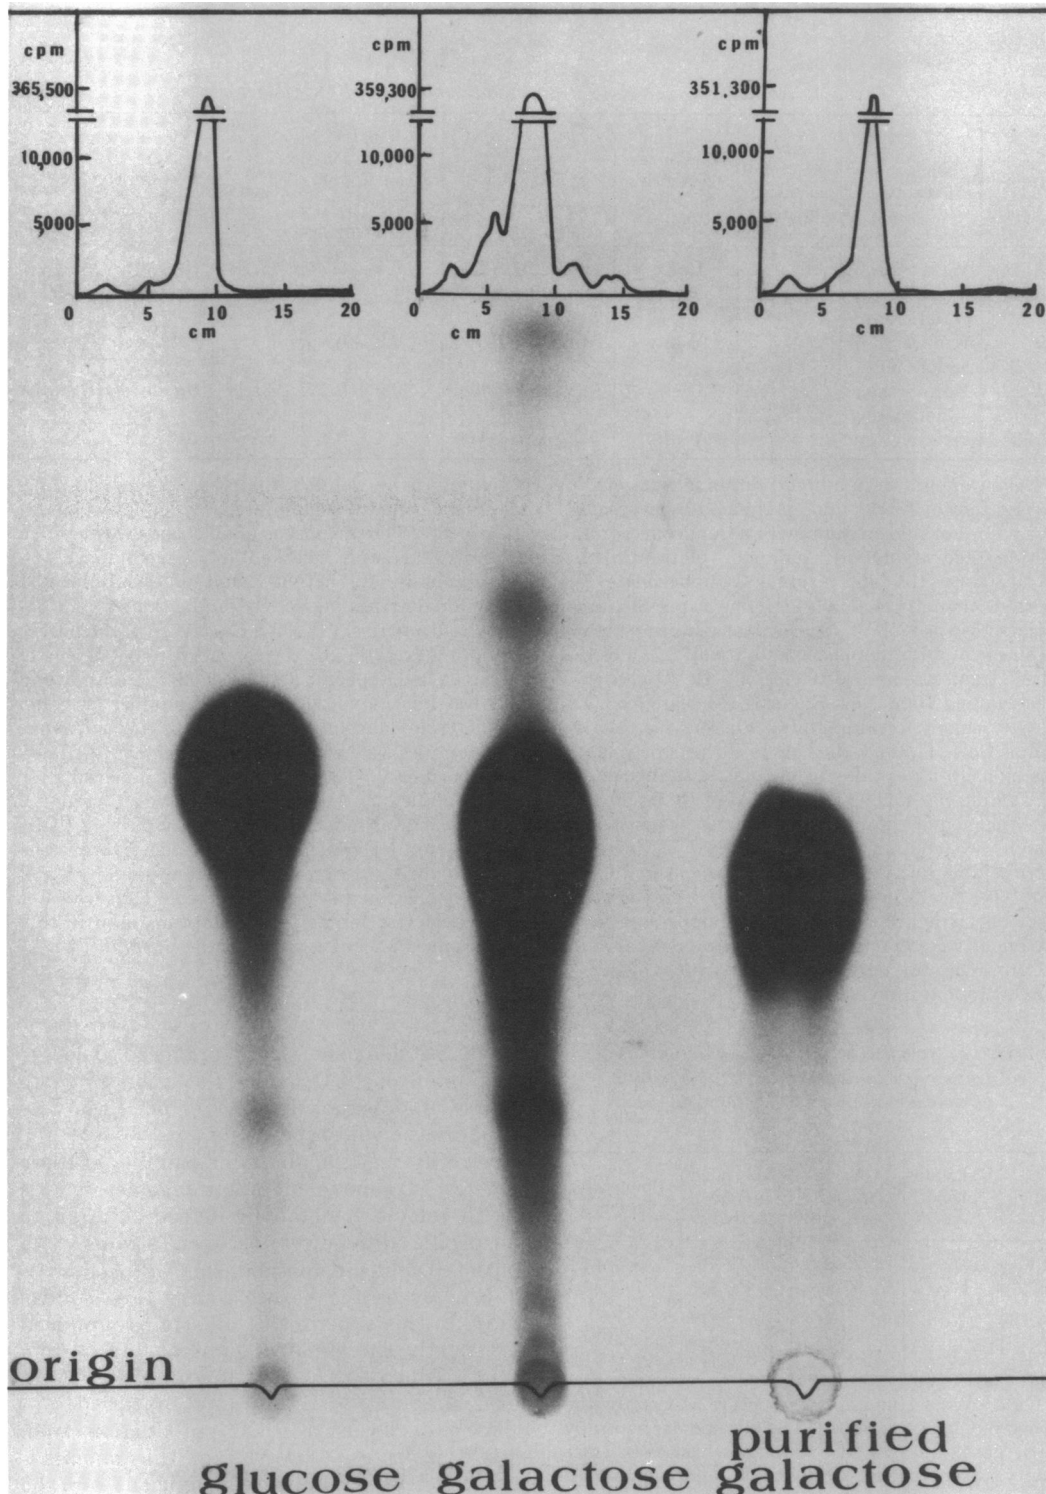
Autoradiogram of thin-layer chromatographic separation of commercial D-[1-¹⁴C]glucose, commercial D-[1-¹⁴C]galactose, and purified D-[1-¹⁴C]galactose. Above each separation is a plot of counts per minute per centimeter of distance from the base of the thin-layer chromatographic plate for that separation. The thin-layer chromatographic plates used were Eastman silica gel without fluorescent indicator. Plates were not washed prior to use. Separation was effected by the Waldi solvent system (n-butanol-acetone-phosphate buffer, pH 5; 40:50:10 [10]). The autoradiogram was made with Kodak No-Screen medical X-ray film. Exposure time was 48 h at 2 C.
